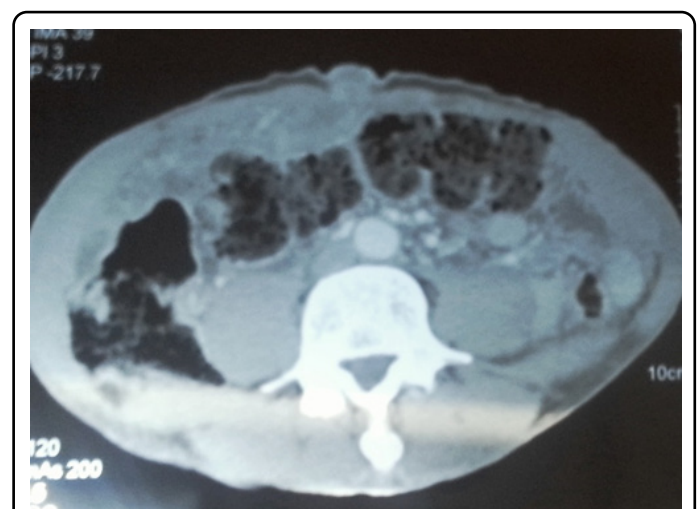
Computed Tomography (CT) revealing Sister Mary Joseph Nodule (SMJN) and a mass involving the head of the pancreas.
